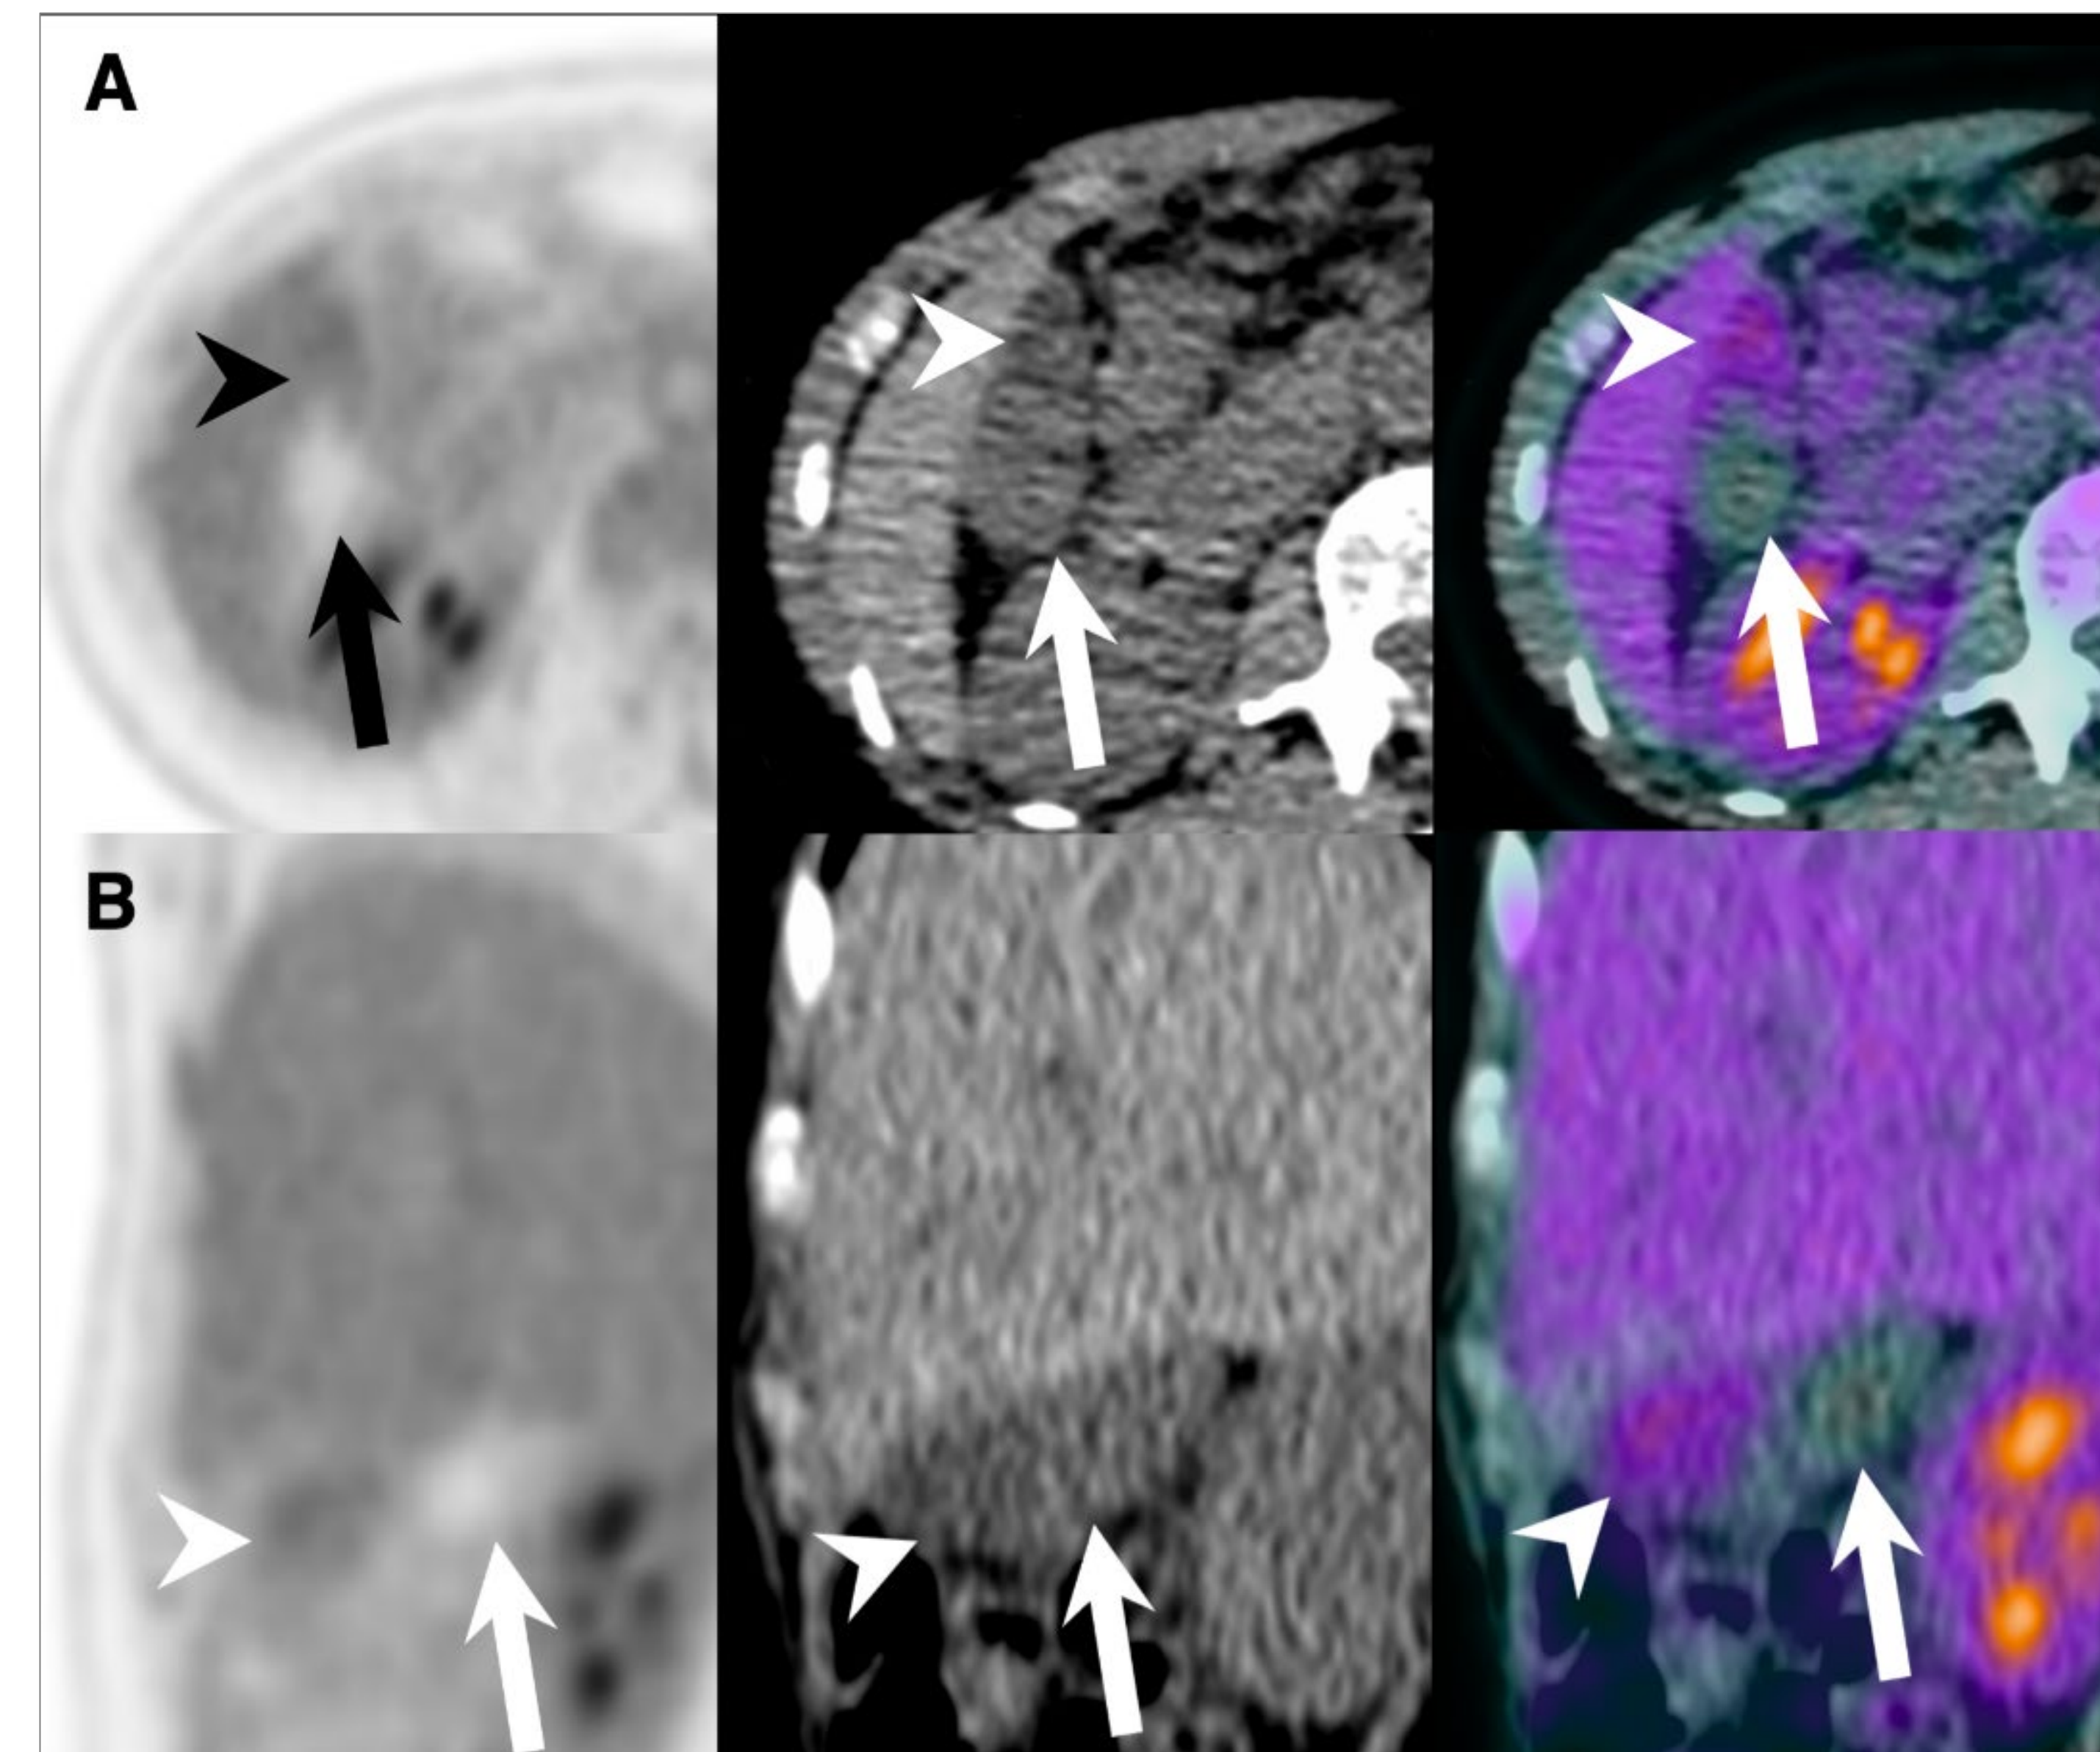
Axial (A) and sagittal (B) PET, CT and fused PET/CT images of a 61 y/o healthy female participant, scanned at 90-minute post-injection of 334 MBq of ¹⁸F-FDG. Images show distribution of ¹⁸F-FDG uptake in the gallbladder: one portion shows uptake with lower attenuation on the corresponding CT (arrowhead), while the other portion shows no uptake and higher attenuation on the corresponding CT (arrow). These findings suggest the presence of different luminal content.
